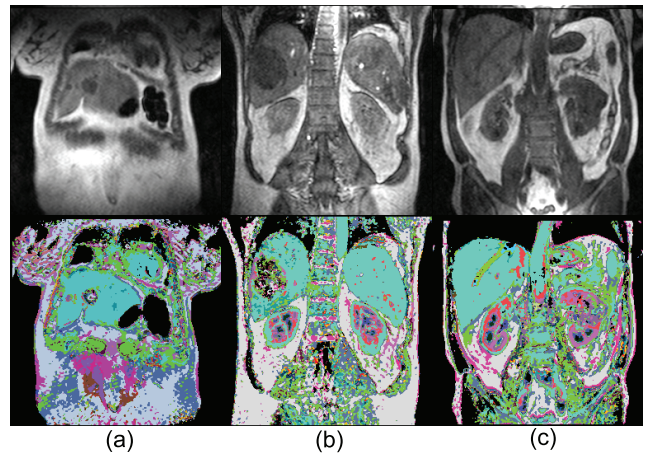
Visualization of dimensionality reduction with a single-layer sparse autoencoder, where the size of the DCE-MRI temporal dimension is reduced from 40 to 16 elements. Different tissue types are visualized in different colors, and a liver tumor is represented as a complex pattern within liver (a), (b). Ambiguities in identifying some tissue types of different organs remain, with some subregions of the aorta, heart, liver, and spleen being represented as the same cyan color.
